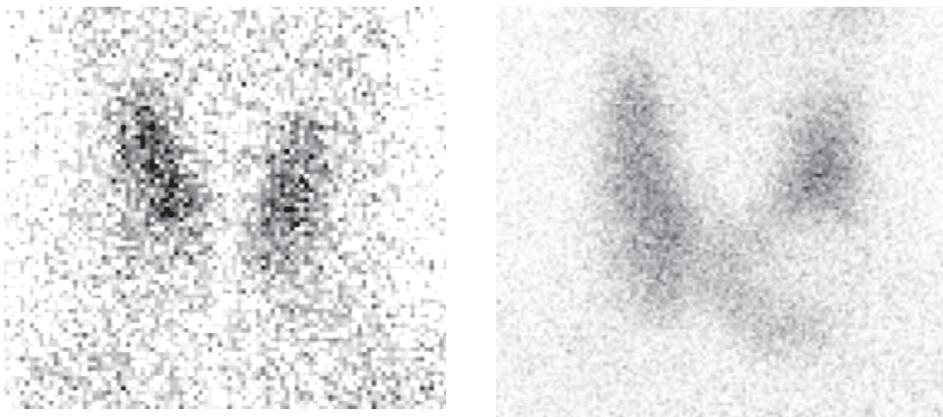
Pertechnetate scintigraphy of the thyroid. Left: normal thyroid scintigram. Right: area of low uptake in the left thyroid lobe, a so called 'cold nodule'.
